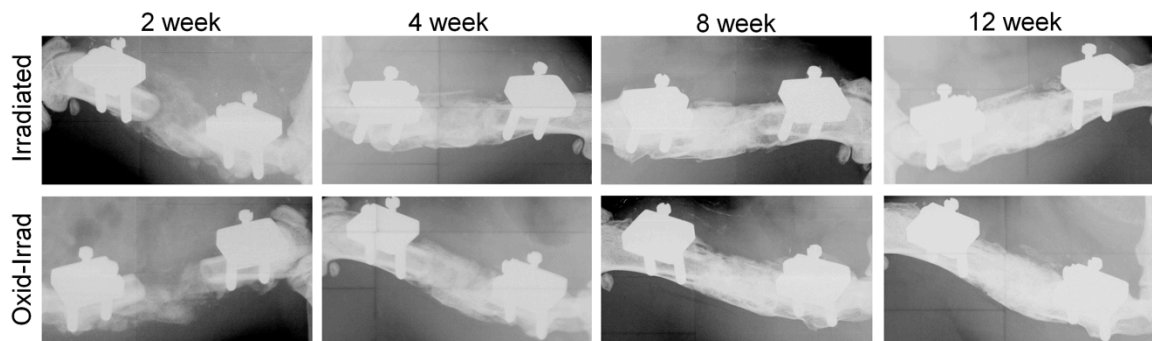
Longitudinal radiographs of bone regeneration. Representative radiographs of defects treated with BMP-2 in irradiated alginate (top) or oxidized-irradiated alginate (bottom) at 2, 4, 8, and 12 weeks post-operatively. All defects showed complete bridging by 8 weeks.
